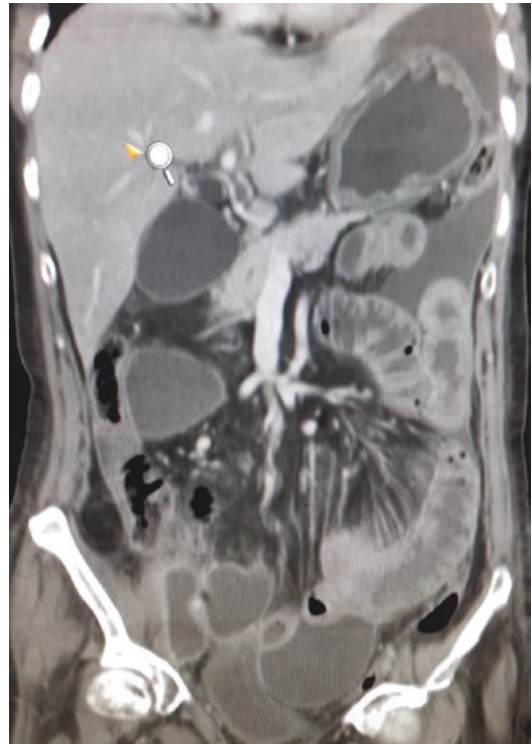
Plain CT scan of patients with peritonitis without bowel perforation. Bowel loops are thickened and dilated
